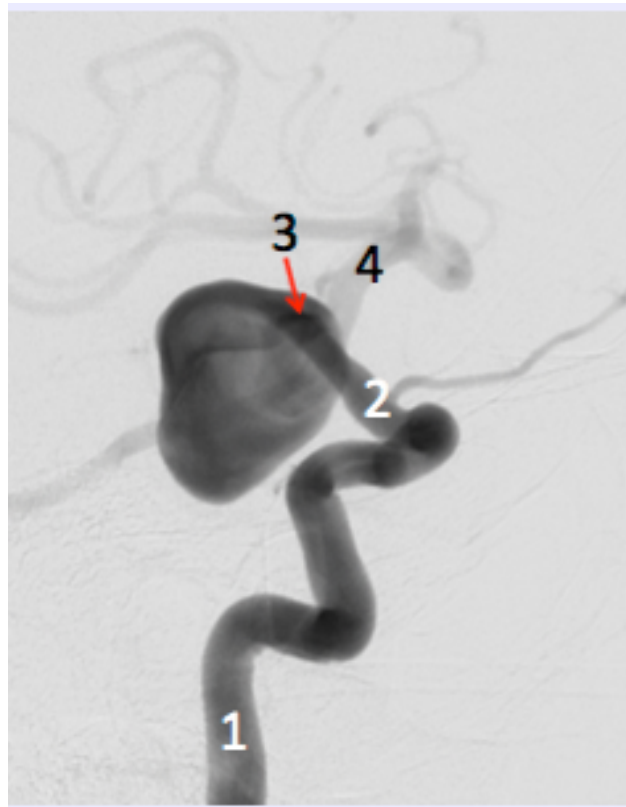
CT generated image of representative patient with large saccular ICA aneurysm. Numbers correspond to locations where Doppler guide wire pressure and velocity measurements are taken
